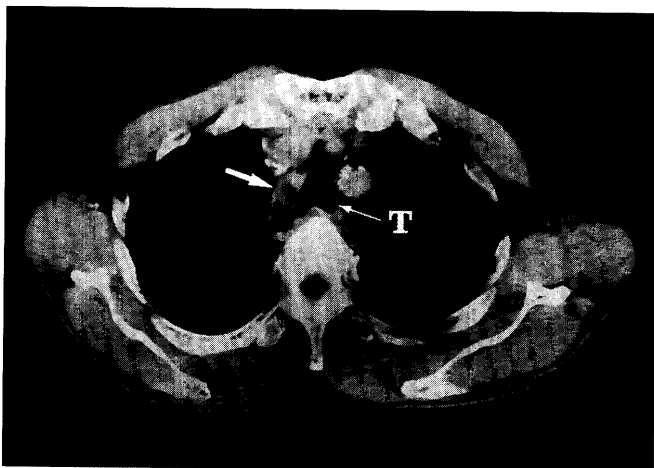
CT showing a metastatic tumor (*arrow*) at the right retro-tracheal space. T indicates the trachea.
